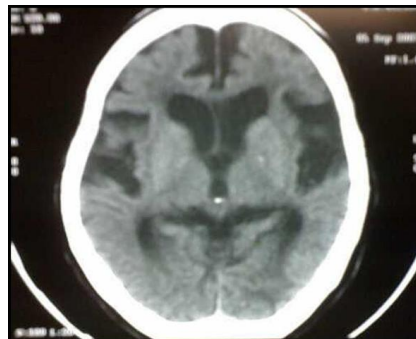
plain CT brain is unremarkable
